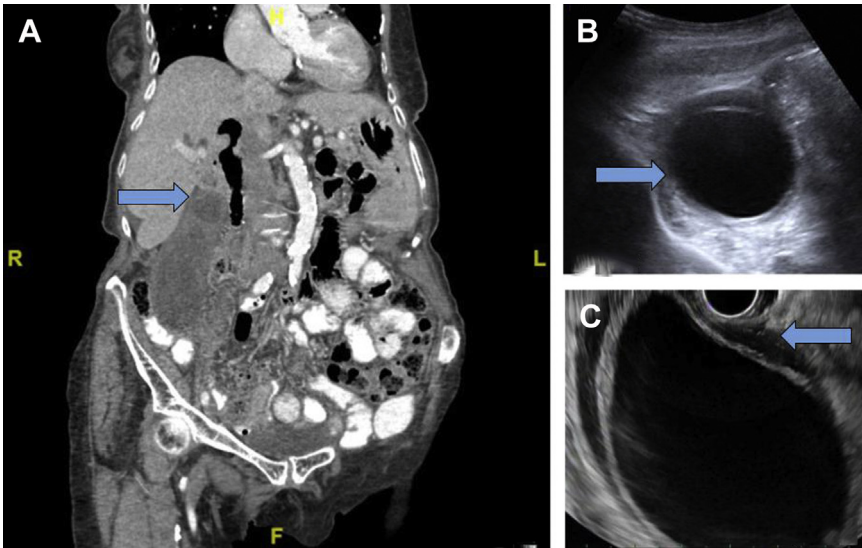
(A) CT scan showing acute cholecystitis (arrows) in a 102-year-old woman. (B) US and (C) endoscopic US (EUS) visualization of acute cholecystitis including pericholecystic fluid.
